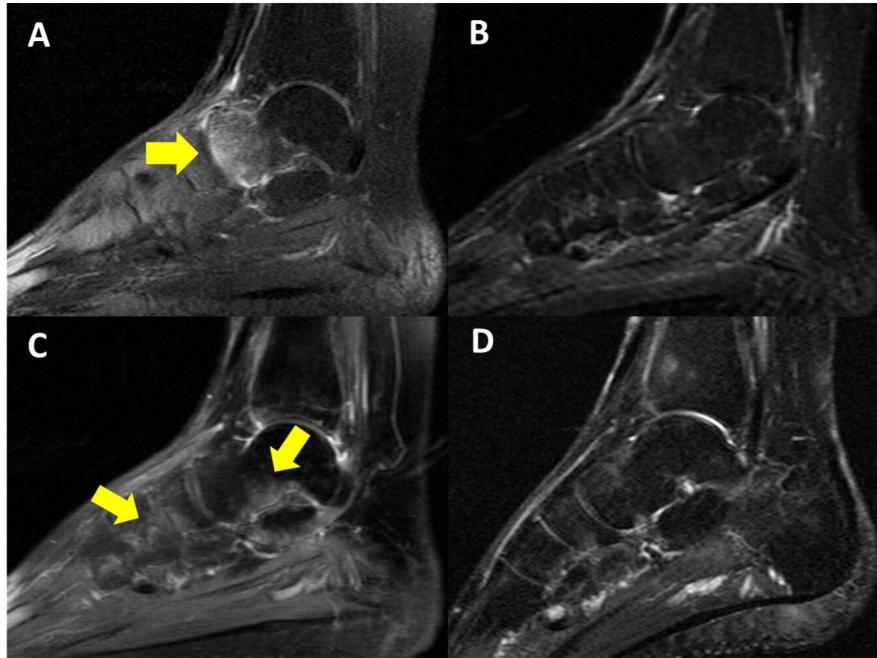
Serial magnetic resonance imaging (MRI) of the left ankle-foot (sagittal T2-weighted) of the patient (A-D). In January 2019, bone marrow edema (BME) was revealed in talus (A, yellow arrow) and conservative treatment with weight-bearing avoidance and analgesics followed. In May 2019, a follow-up MRI showed resolution of the BME (B). After 2 months, the local pain relapsed and a new MRI displayed periarticular (subchondral) BME (yellow arrows) in the bones of the left ankle and the foot (C). Three-and-a-half months after a 5mg zoledronic acid infusion the BME has almost completely resolved (D).
